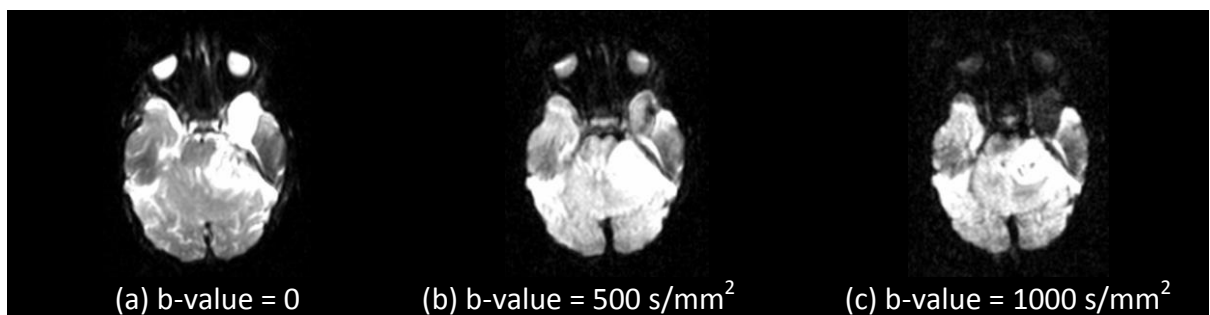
The difference of imaging features and deterioration of SNR-based DWI at b -value = 0, 500 and 1000 s/mm² (case MB950).
